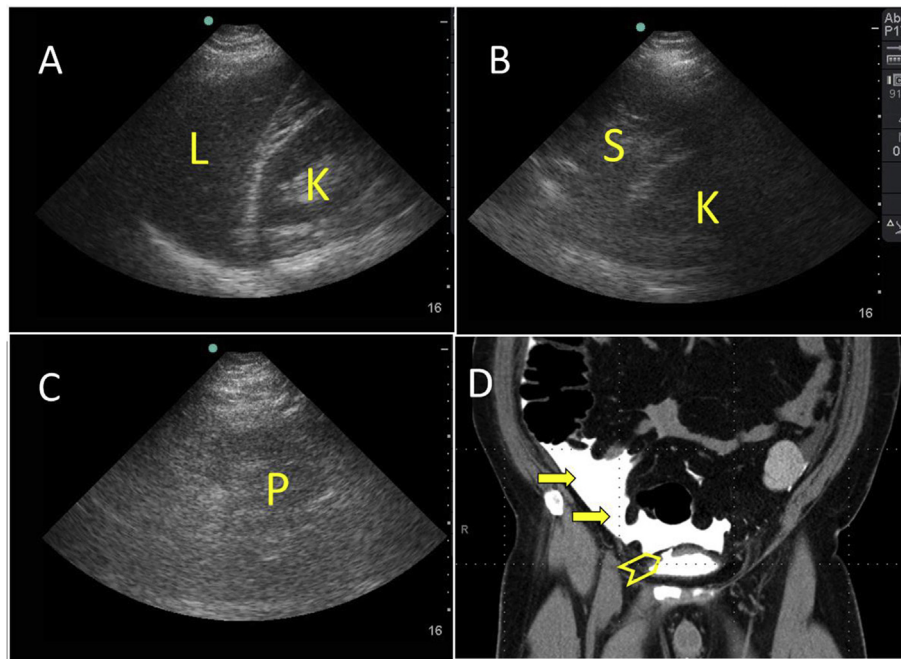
Repeated FAST scan after insertion of a Foley catheter shows absence of intra-peritoneal fluid in the right upper quadrant (A) and left upper quadrant of the abdomen (B), and pelvis (C). The urinary bladder could not be visualized. CT scan (D) which was performed after contrast was instilled through the Foley catheter shows significant spillage of contrast (arrows) into the peritoneal cavity from the dome of the urinary bladder (arrow head). L = Liver, K = Kidney, S = Spleen, P = Pelvis.
